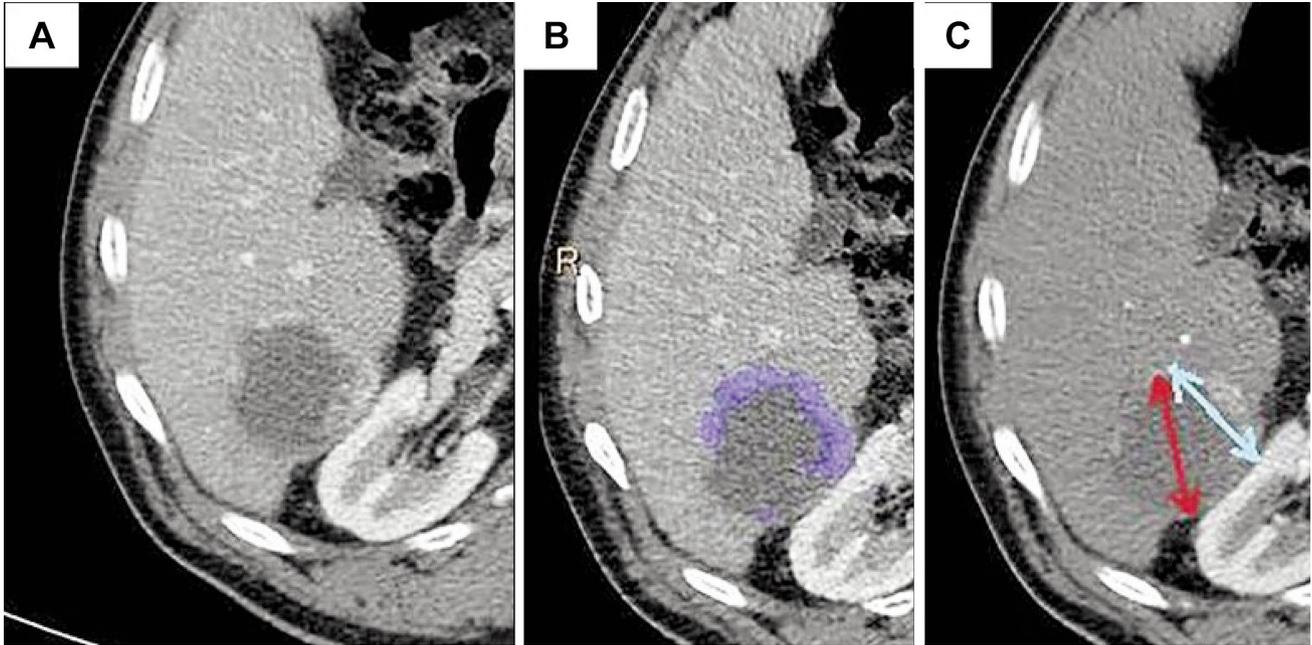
Hepatocellular carcinoma after a single session of TACE. (A) CT scan 3 weeks after the procedure. (B) Measurement using volumetric analysis. (C) Measurement using RECIST (red arrow) and mRECIST (blue arrow).
